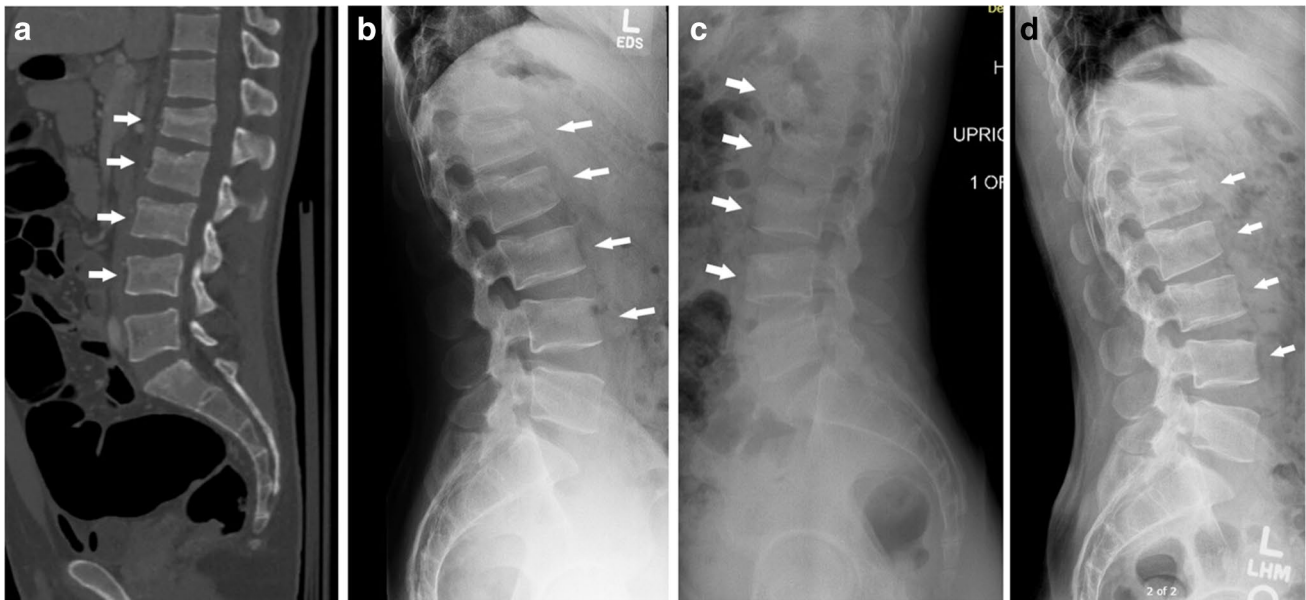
a Sagittal CT and b initial upright lateral radiograph of an adult male patient with L1-4 compression fractures who was neurologically intact on presentation. c Three-week and d 6-month upright radiographs were obtained to monitor stability and recovery
